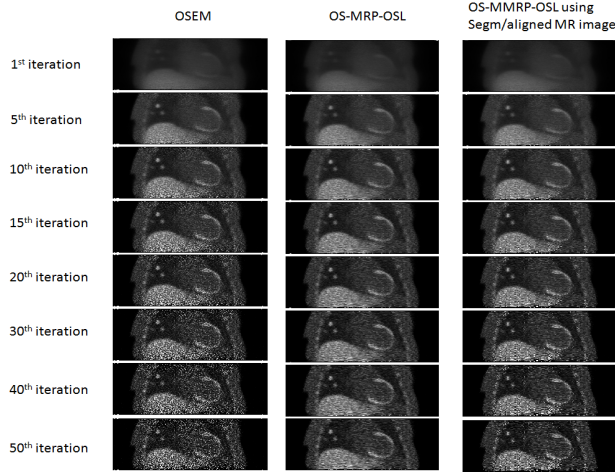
Coronal views of three algorithms over iterations: i) OSEM results (left column), ii) OS-MRP-OSL with $\beta=60$ (middle column), iii) OS-MMRP-OSL with $\beta=60$ using the perfectly aligned and segmented MR image (right column). Min=0 and max=5
